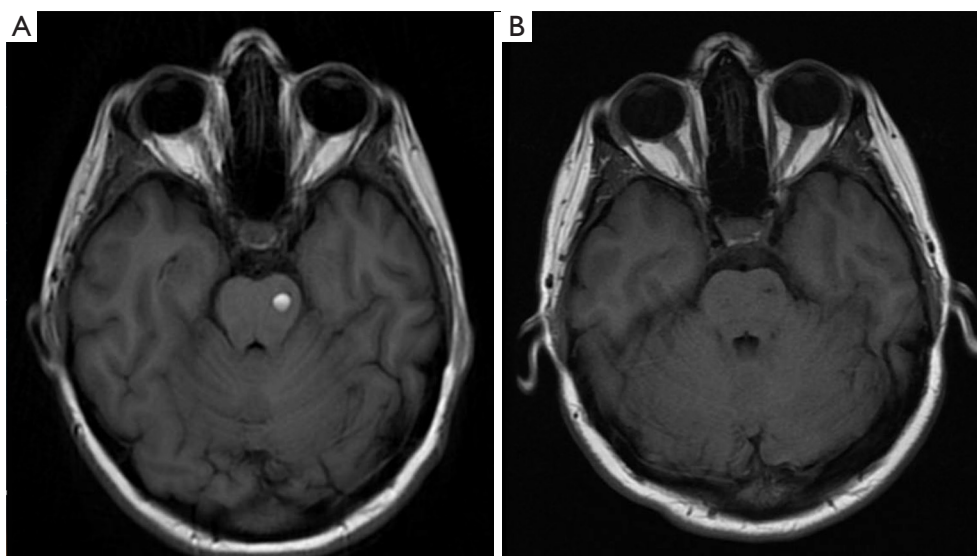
Axial T1-weighted MRI of pontine metastasis before and after radiosurgery. (A) Melanoma metastatic to the pons resulting in a 6 mm left pontine lesion causing hemiparesis. (B) This lesion was treated with single fraction linear accelerator-based radiosurgery, and 6 months later, the lesion involuted and resolved. MRI, magnetic resonance imaging.
